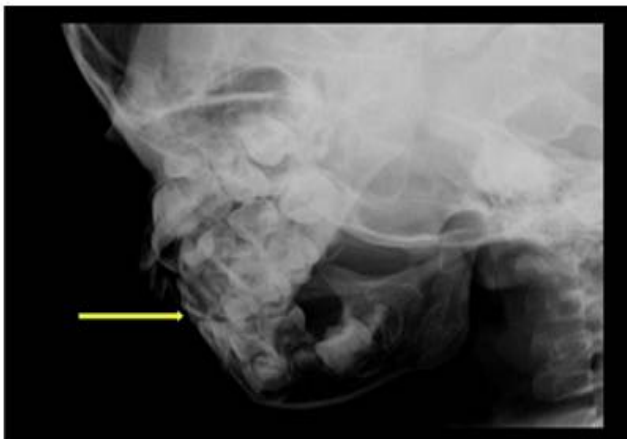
X-ray mandible – lateral oblique view with fracture parasymphysis
